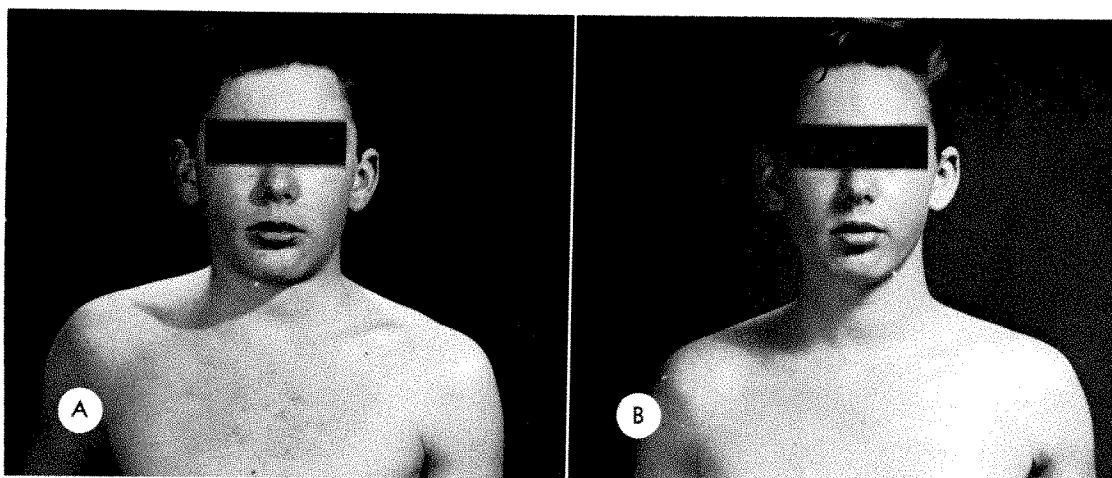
Case II. (A) Appearance on admission to the hospital. There is edema of the face and neck (with narrowing of the palpebral fissures) and fullness of the neck. The lateral transthoracic diameter is increased and the ribs are prominent, reflecting pronounced emphysema. (B) After treatment. There is striking difference in the facies and habitus, once the superior mediastinal structures have been relieved of compression by the tumor.
